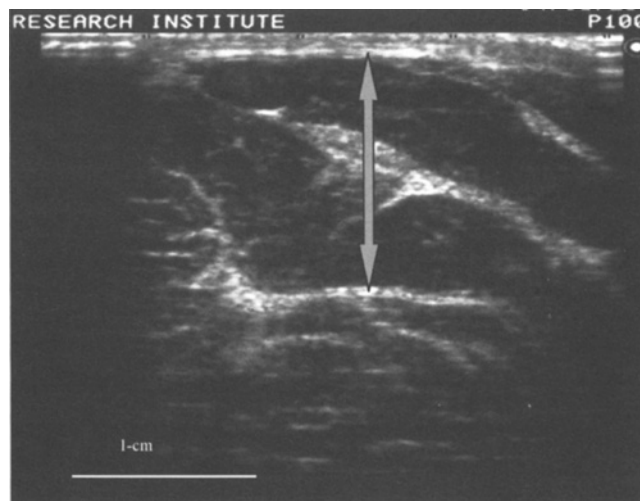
Ultrasound image of the extensor digitorum communis (EDC). Ultrasound-measured muscle thickness of the EDC is indicated by the arrow.
